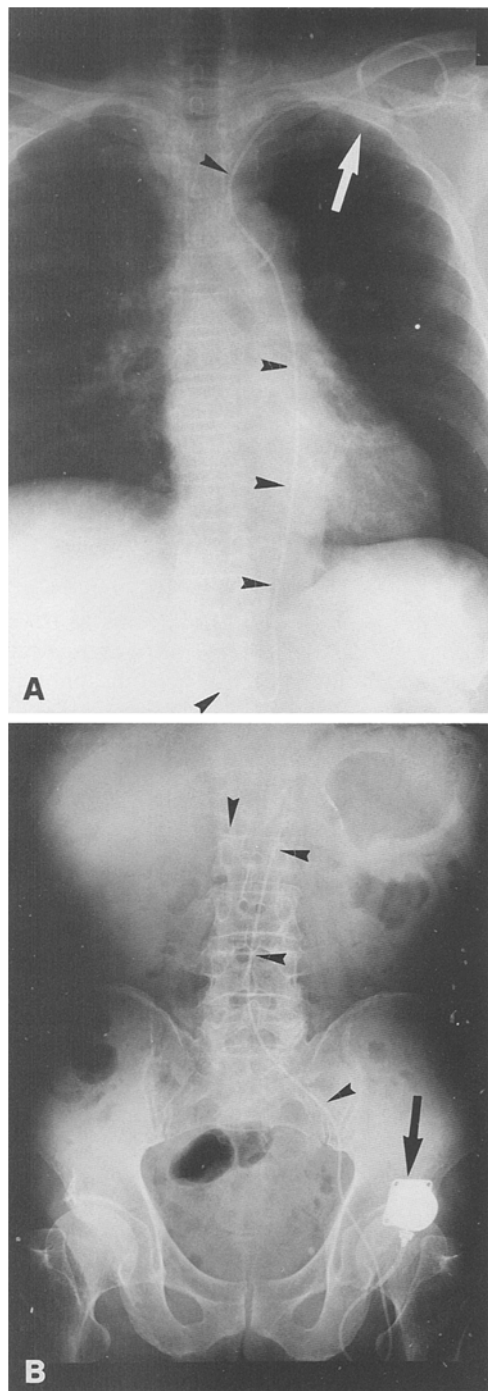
A, B. Radiographs obtained after implantation of the reservoir and embolization with steel coils in the gastroduodenal artery through A subclavicular and B inguinal approaches. The *arrowheads* indicate the indwelling tube in the hepatic artery, and the *arrow* shows the subcutaneously implanted reservoir
